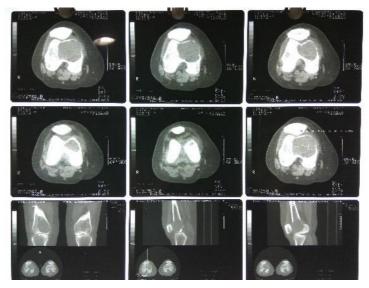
Post GCT curettage and cementation - CT images
